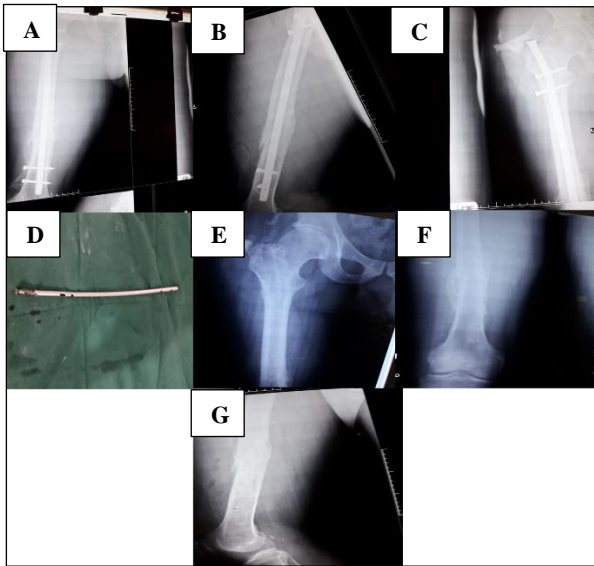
Plain radiographic views of united femoral fracture with intramedullary nail in situ (2A and 2B) showing heterotopic calcification and overgrowth at the proximal tip of the nail (2A and 2C). Removed intramedullary nail with bolt in situ (2D). Plain radiographs of the femur after nail removal (2E-2G).
